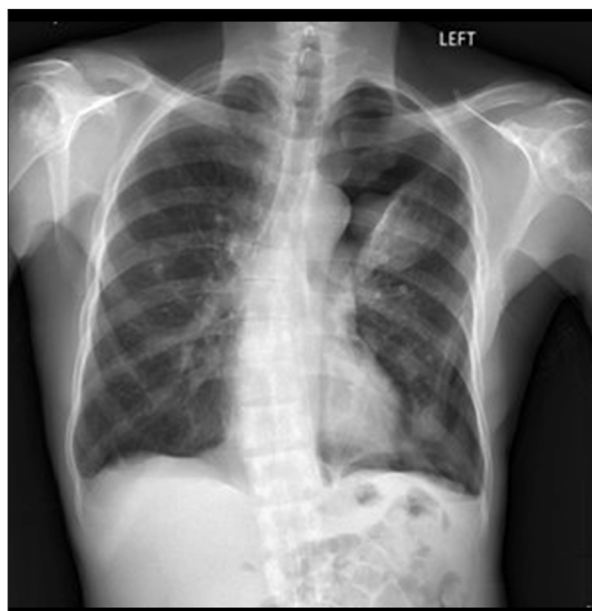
Chest X-ray showing a large left-sided pneumothorax with some associated pleural fluid, left upper-lobe opacity, and round opacity in the anterior aspect of the right upper lobe.
